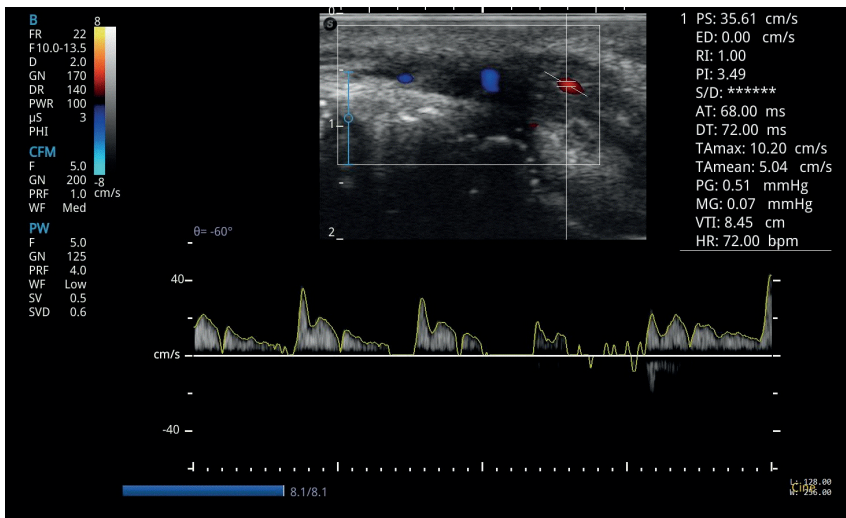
Doppler of the patient S. of the comparison group, in 6 months from the beginning of treatment
